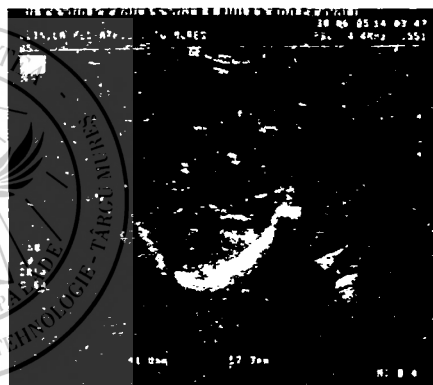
Portal cavernoma – ultrasound aspect
